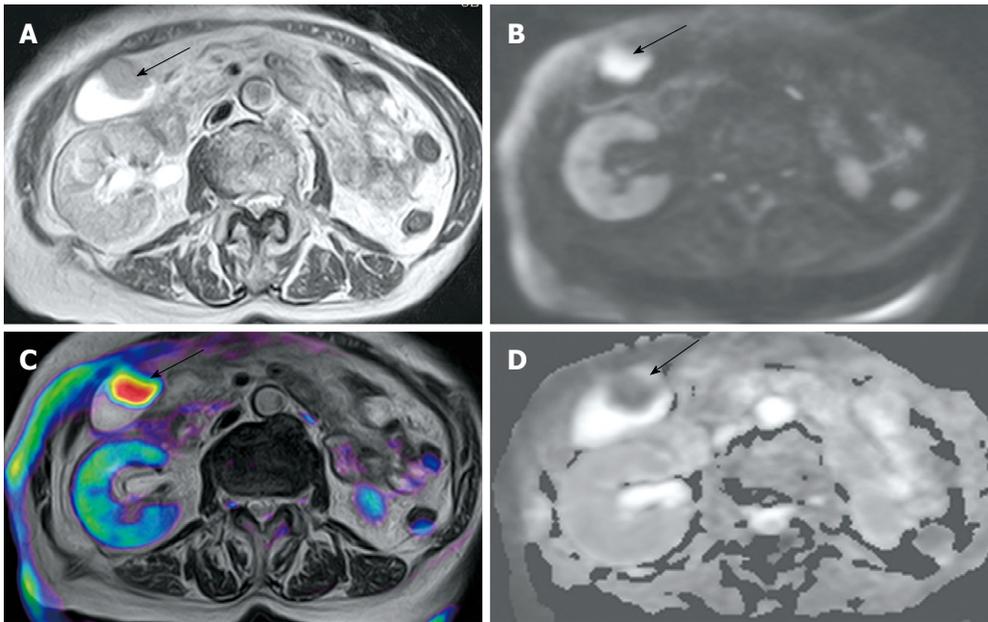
MRI of a patient with gallbladder carcinoma. A: Axial T2-weighted MRI of a patient with gallbladder carcinoma shows a mass (arrow) protruding into the gallbladder lumen; B: Corresponding axial DW image shows high intensity (arrow); C: Corresponding color fusion image of T2-weighted image and DW image shows gallbladder carcinoma (arrow). On color fusion images, the red area corresponds to high signal intensity on DW images and blue correspond to low intensity; D: Corresponding ADC map shows low intensity (arrow).
